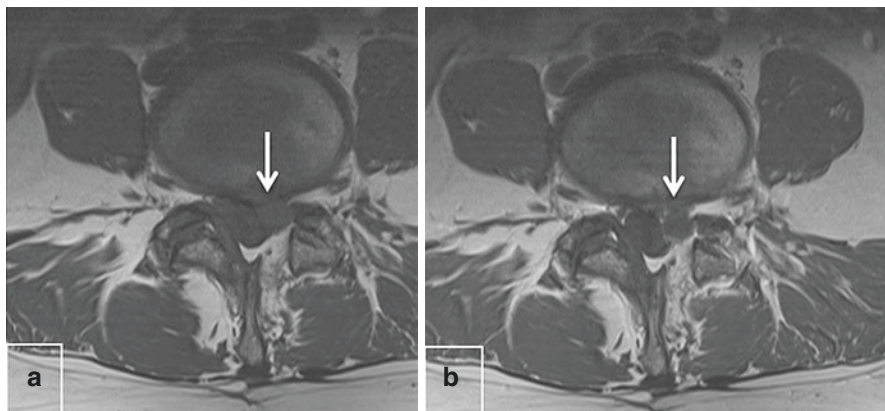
Axial T1 (a) and T1 post contrast (b) image of the lumbar spine in a patient with previous micro-discectomy. There is soft tissue seen in the left lateral recess, which does not enhance post contrast in keeping with a recurrent disc herniation. This is easily differentiated from postoperative epidural fibrosis on contrast-enhanced MRI as the recurrent disc is avascular and does not enhance post contrast
